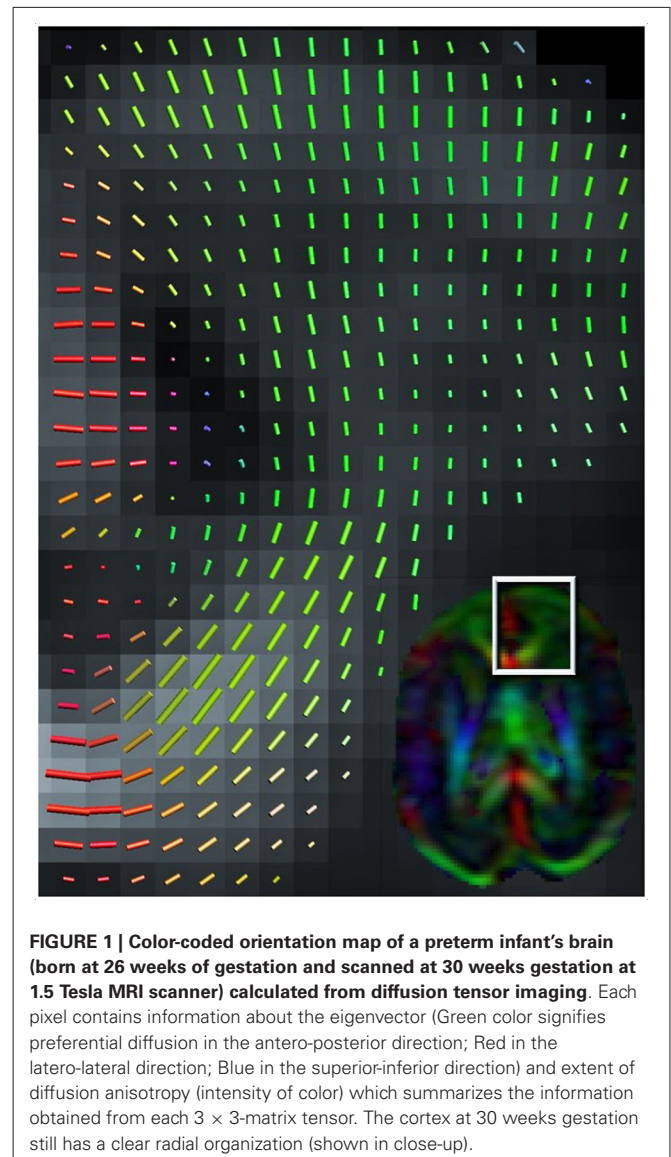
Color-coded orientation map of a preterm infant's brain (born at 26 weeks of gestation and scanned at 30 weeks gestation at 1.5 Tesla MRI scanner) calculated from diffusion tensor imaging. Each pixel contains information about the eigenvector (Green color signifies preferential diffusion in the antero-posterior direction; Red in the latero-lateral direction; Blue in the superior-inferior direction) and extent of diffusion anisotropy (intensity of color) which summarizes the information obtained from each 3×3 -matrix tensor. The cortex at 30 weeks gestation still has a clear radial organization (shown in close-up).
